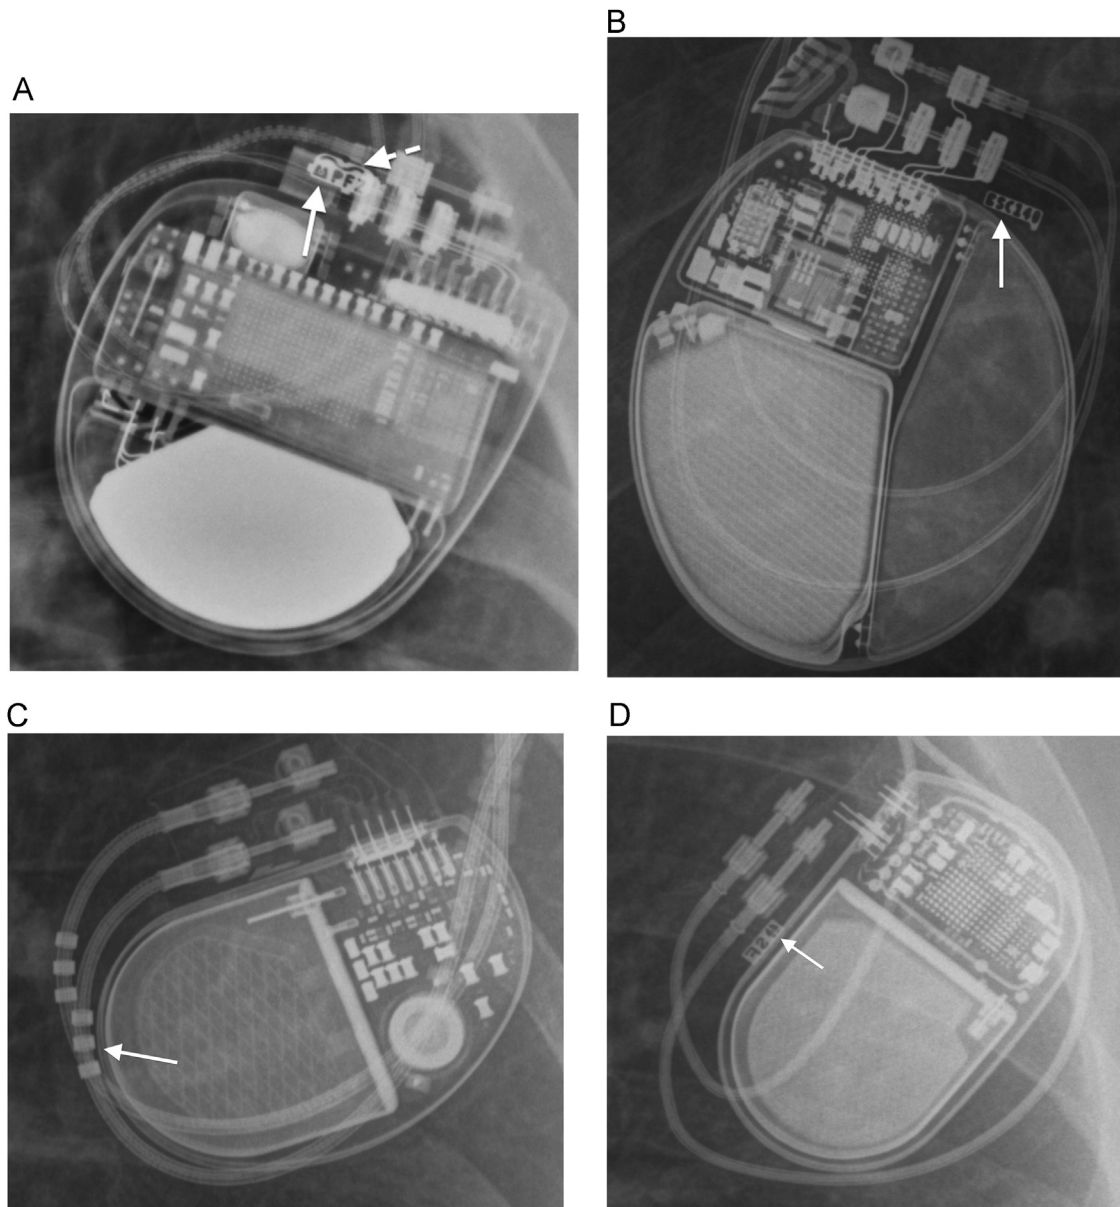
Chest radiographs with magnification of the generator and characteristic radiographic markings. (A) Medtronic device with the Medtronic symbol (solid arrow) and magnetic resonance conditional marking (dashed arrow). (B) Boston Scientific device with characteristic radiographic marking (solid arrow). (C) St. Jude dual-chamber device with magnetic resonance conditional leads denoted by the 3 radiographic rings (solid arrow). (D) Biotronik device and symbol (solid arrow).
